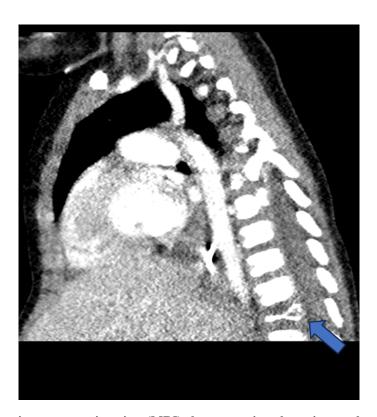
Magnetic resonance imaging (MRI) demonstrating thoracic vertebra involvement (shown by arrow).
